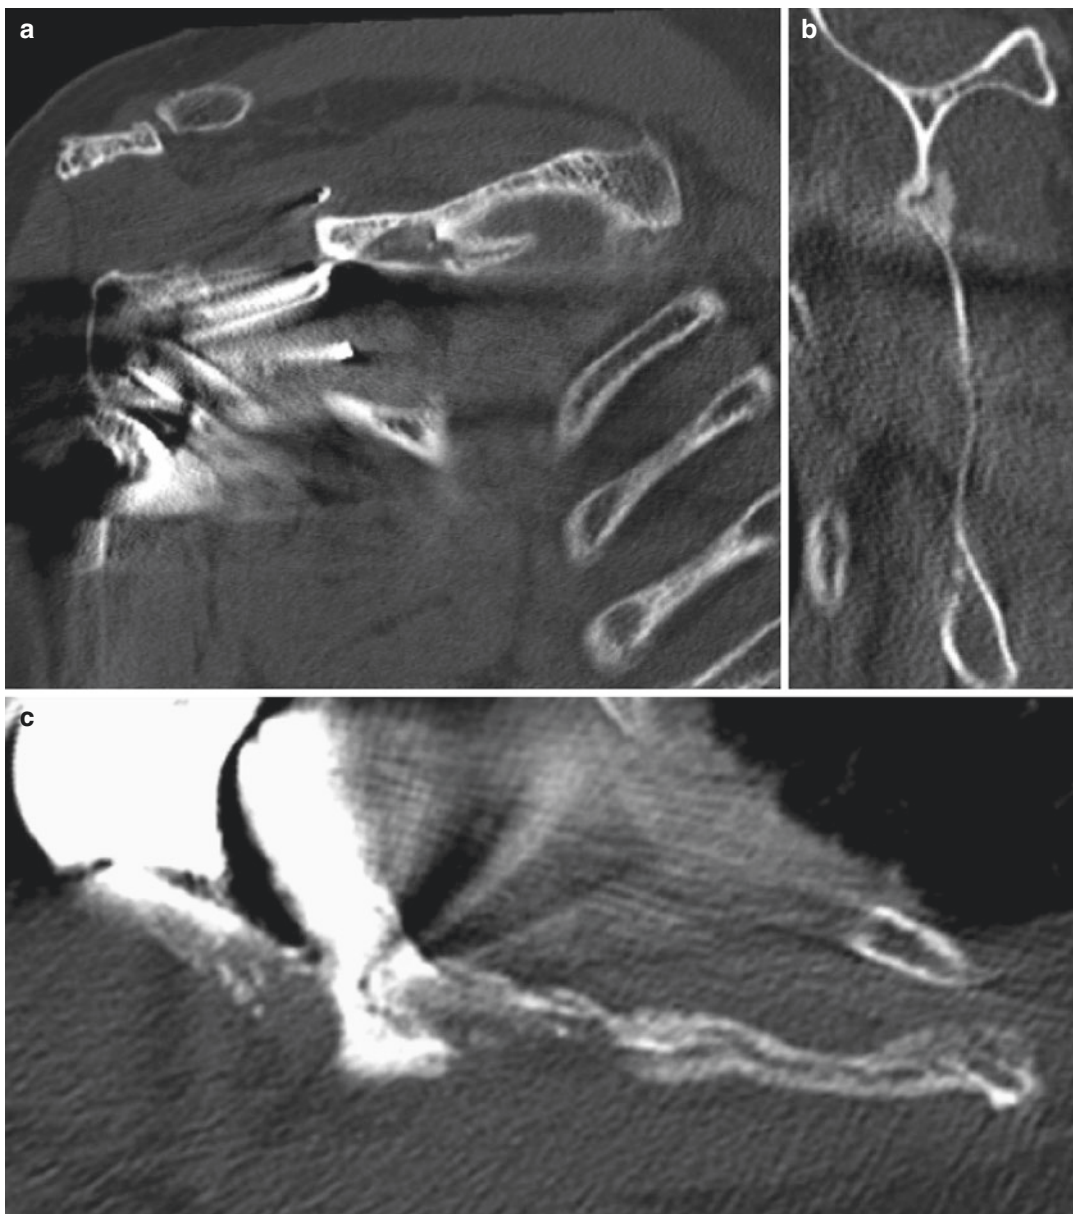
These coronal (a), sagittal (b), and axial (c) computed tomographic cuts demonstrate a postoperative scapula fracture with placement of the central peg within the scapular spine
